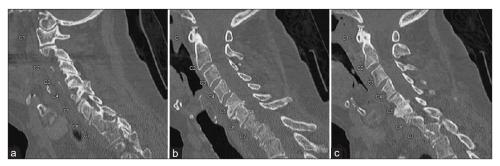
Sagittal cervical spine computed tomography scans demonstrating a T1 Chance fracture (panel (a), left of midline; panel (b), midline, panel (c), and right of midline).
